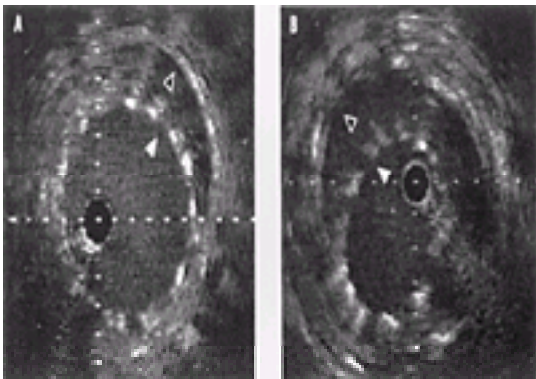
Intravascular ultrasonogram of an arterial wall (black arrowhead) and an intraluminal stent (white arrowhead) showing imprecise apposition.
